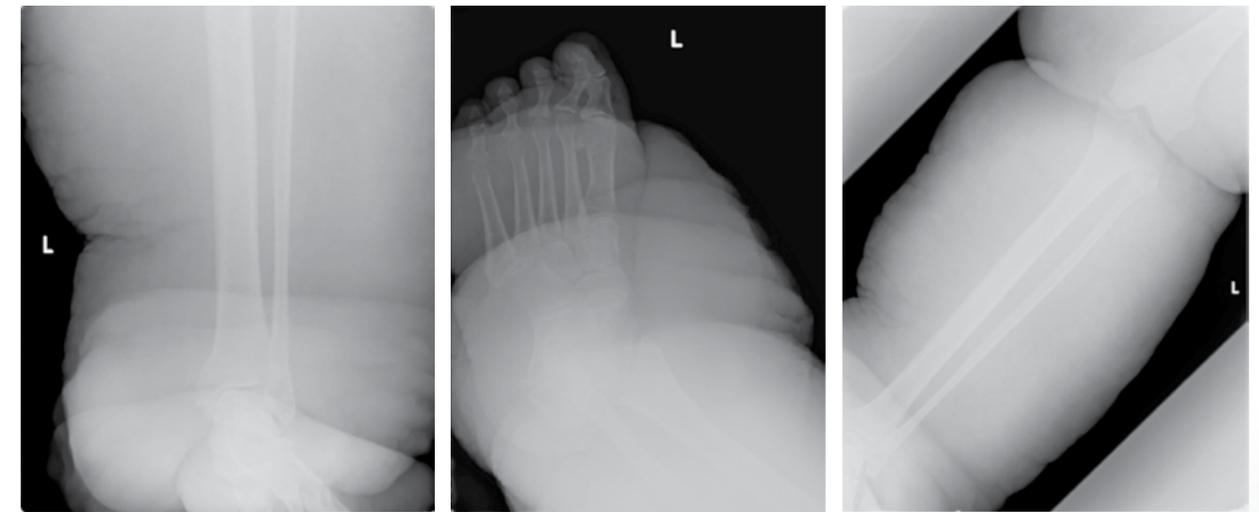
Radiographic images of patient's lower limbs.
